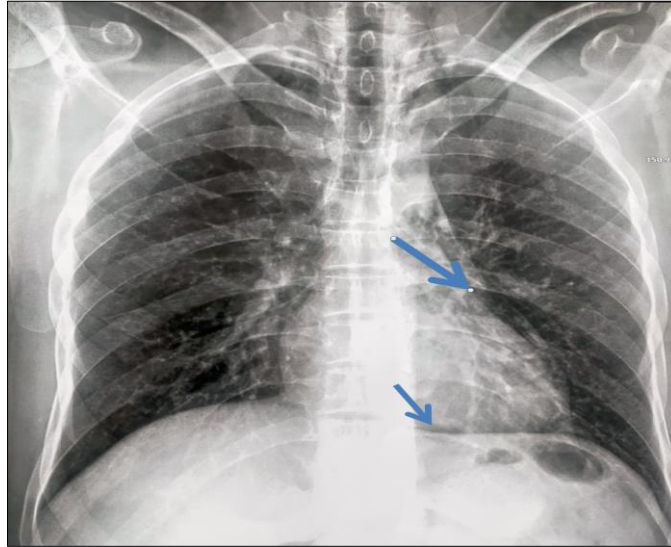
Frontal chest X-ray showing Isolated pneumomediastinum
